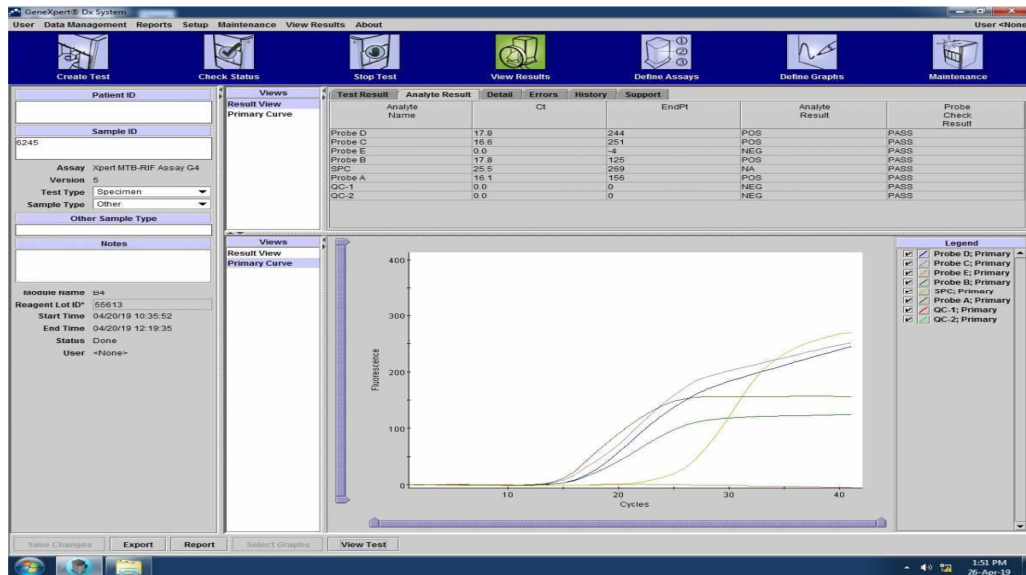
CT values from CBNAAT results can be seen in the second column
